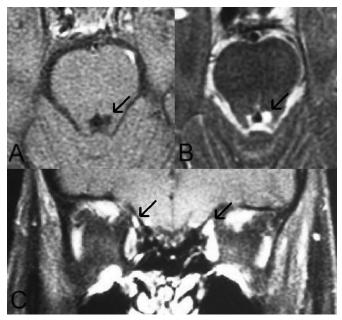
(A) Axial T1-weighted MRI of the brainstem showing a hypointense lesion (arrow) in the region of the left trochlear nerve nucleus. (B) Same lesion (arrow) is hyperintense on T2-weighted images. (C) Coronal T1-weighted MRI of the orbits after gadolinium administration showing substantial asymmetry in the size of the superior oblique muscles (arrows), consistent with denervation atrophy of the right superior oblique muscle.
